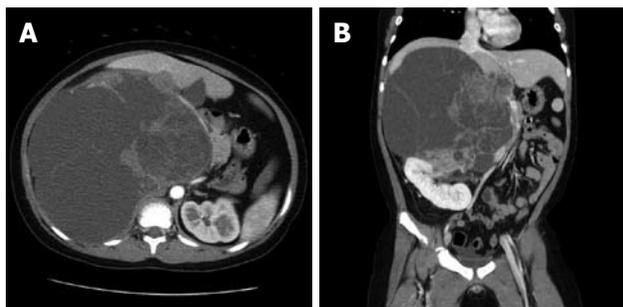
CT (A and B) shows a septated, very large (about 21.8 cm × 16.7 cm), predominantly cystic, lobulated mass in the right upper quadrant between the liver and the right kidney.
